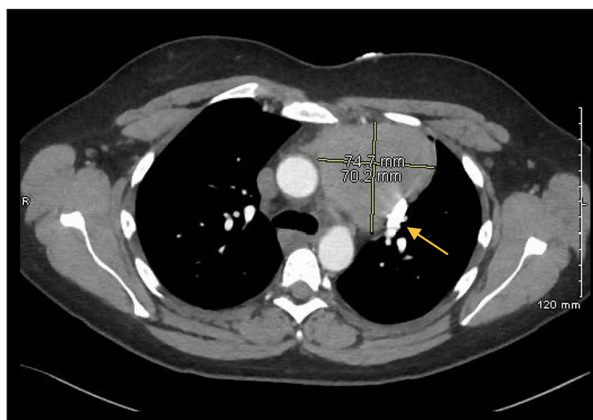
Computed tomography imaging conducted 1 month prior to surgical resection. Mass measuring 7.3×7.6 cm. Arrowhead indicates persistent left superior vena cava.
